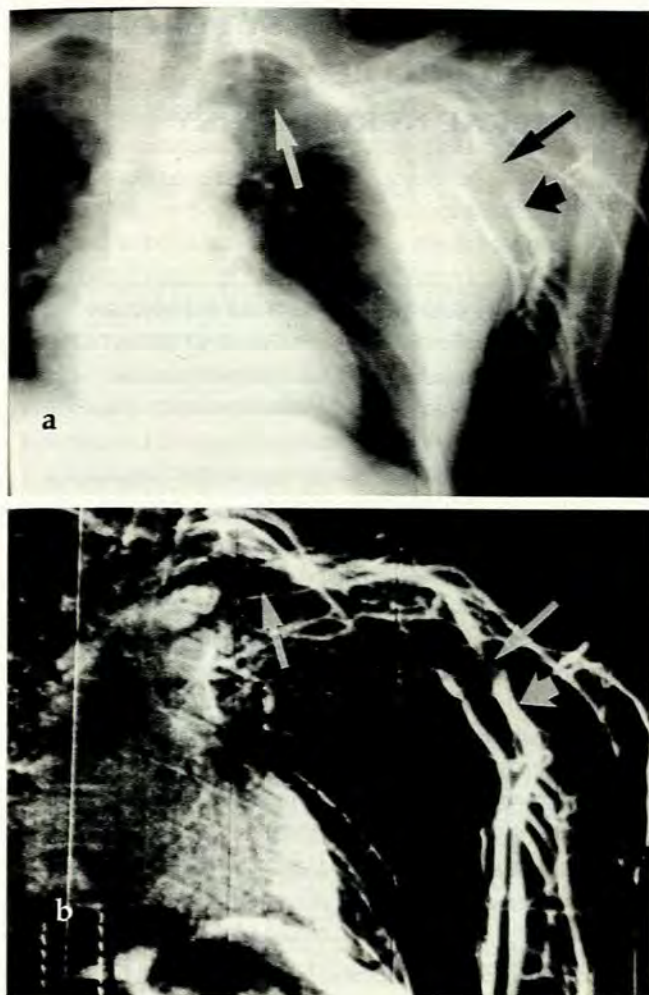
Digital radiograph of upper limb venography before (a) and after (b) digital subtraction. Note the improved visualisation of the veins (broad arrow) and areas of venous obstruction (medium arrows) on the subtracted image (b).
